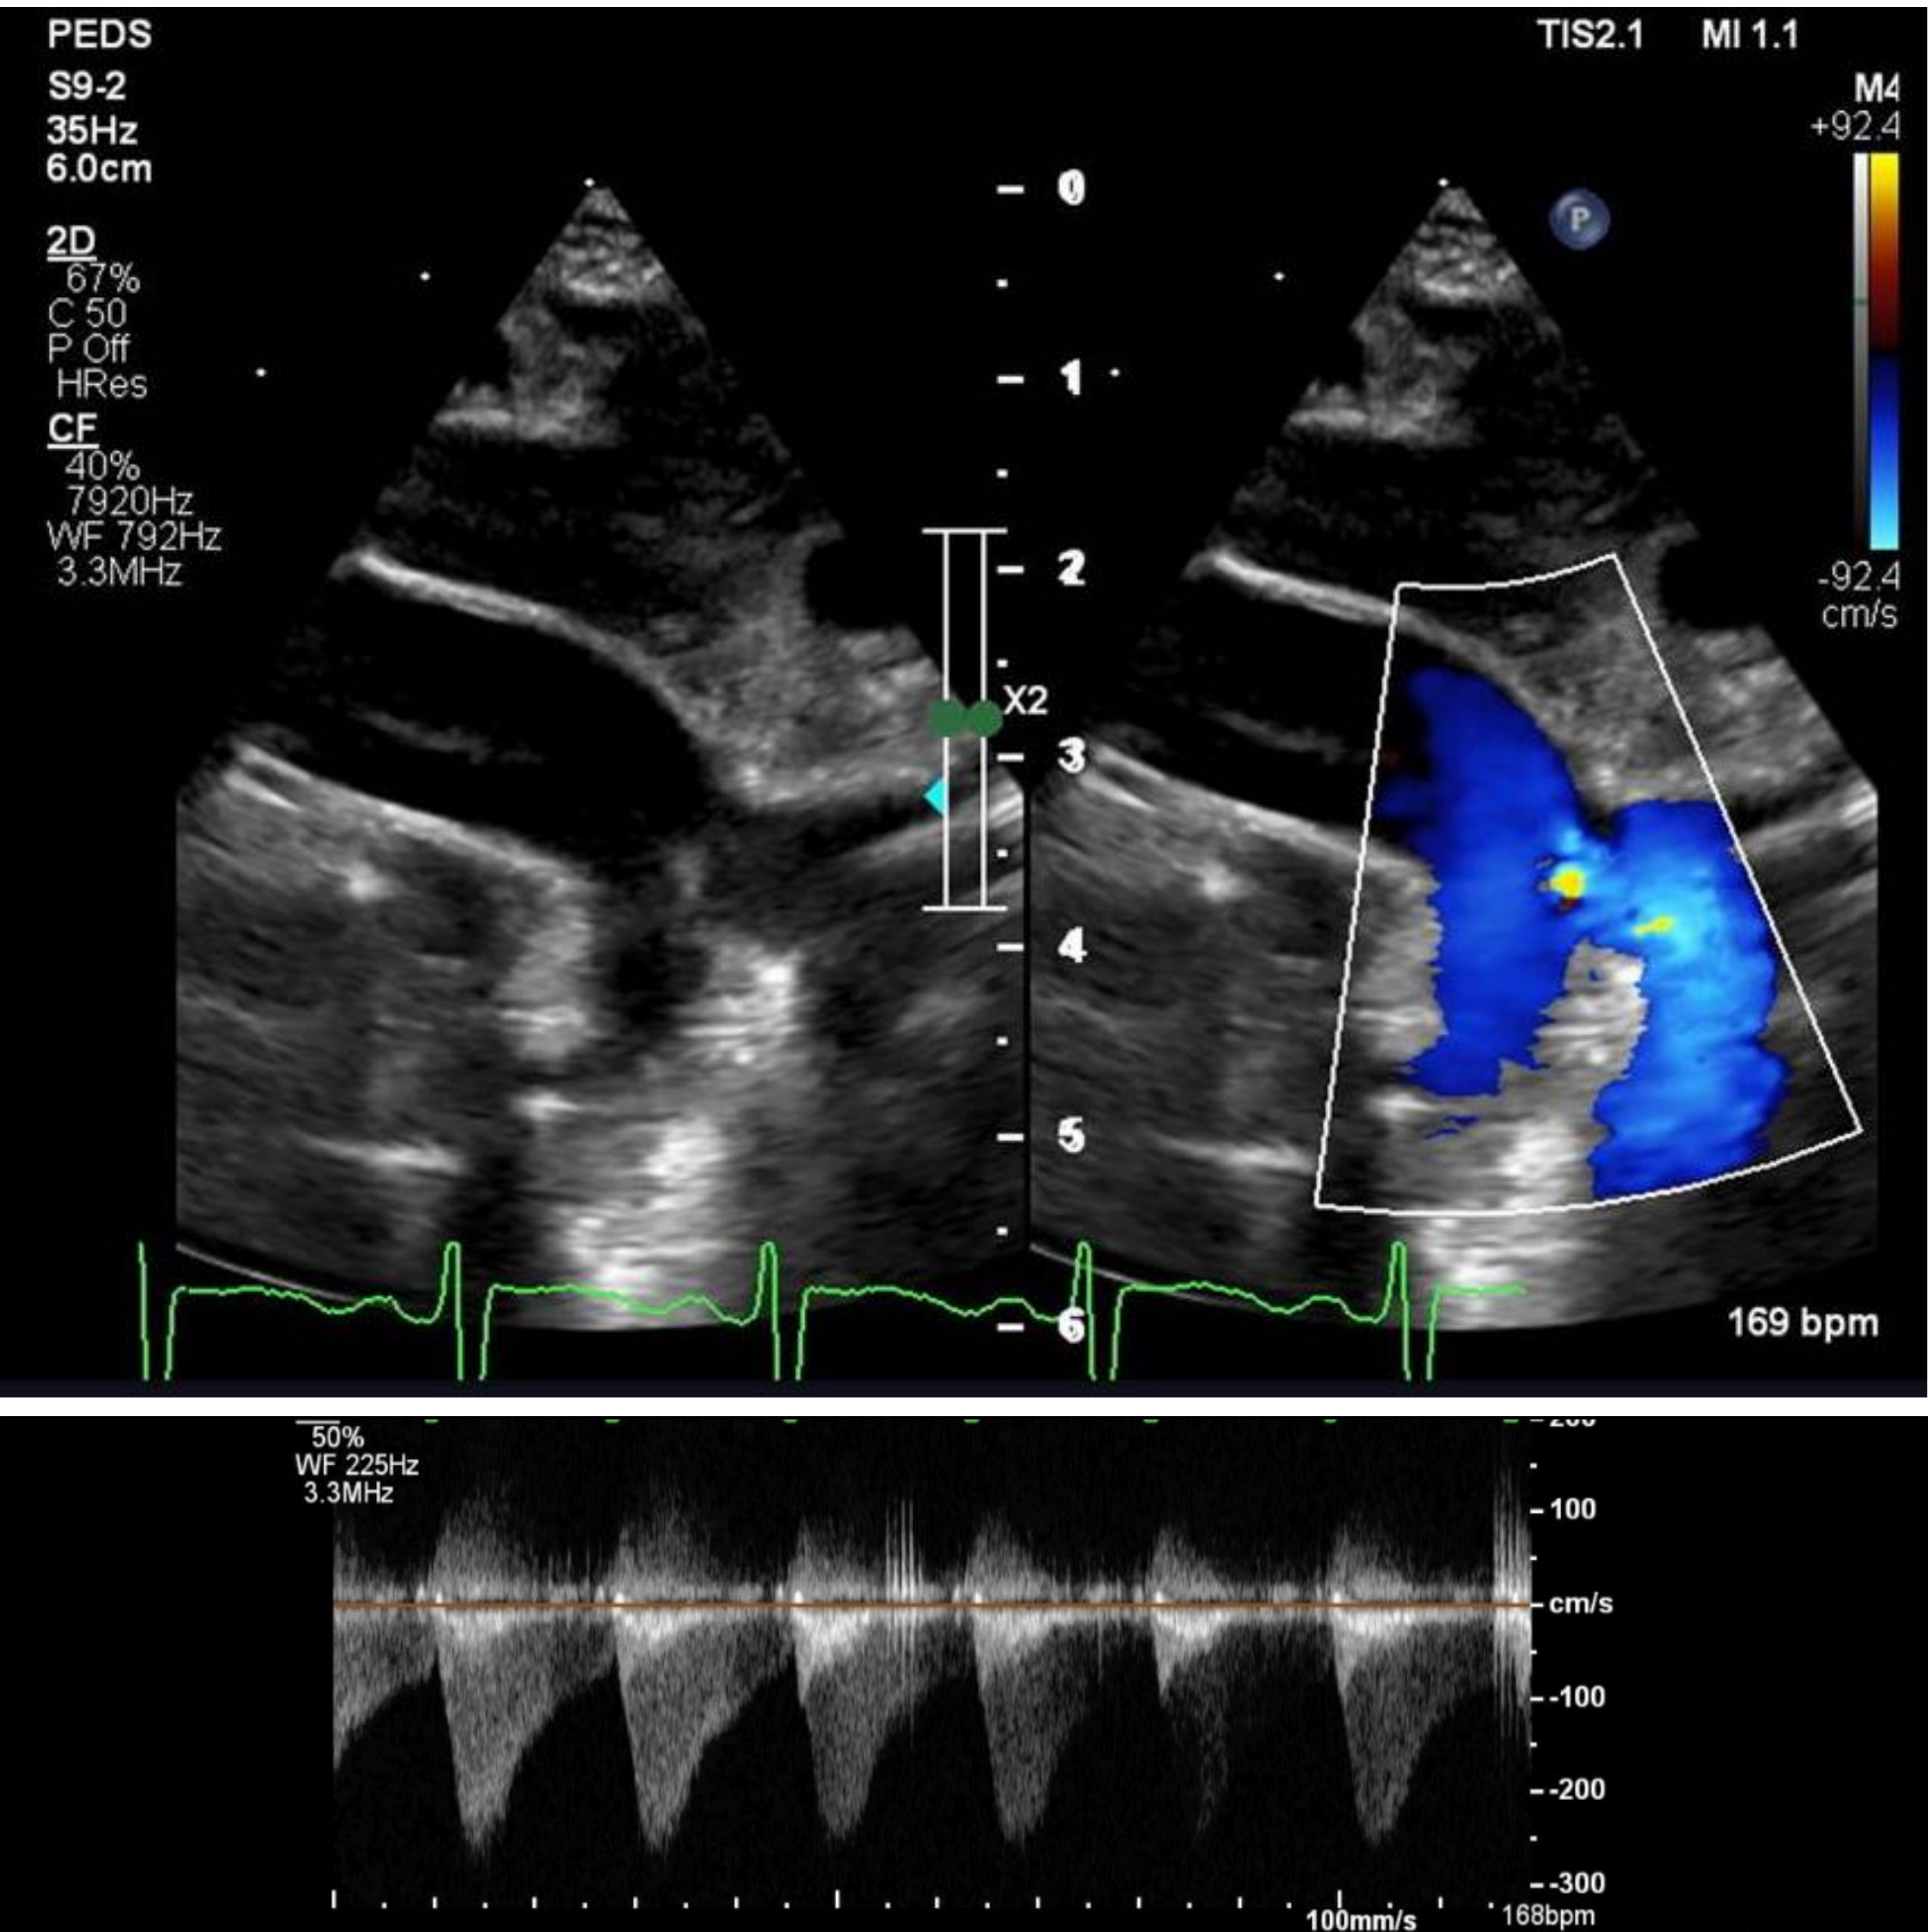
Echocardiogram with doppler at 1 month of life demonstrating all left to right shunting across the PDA
